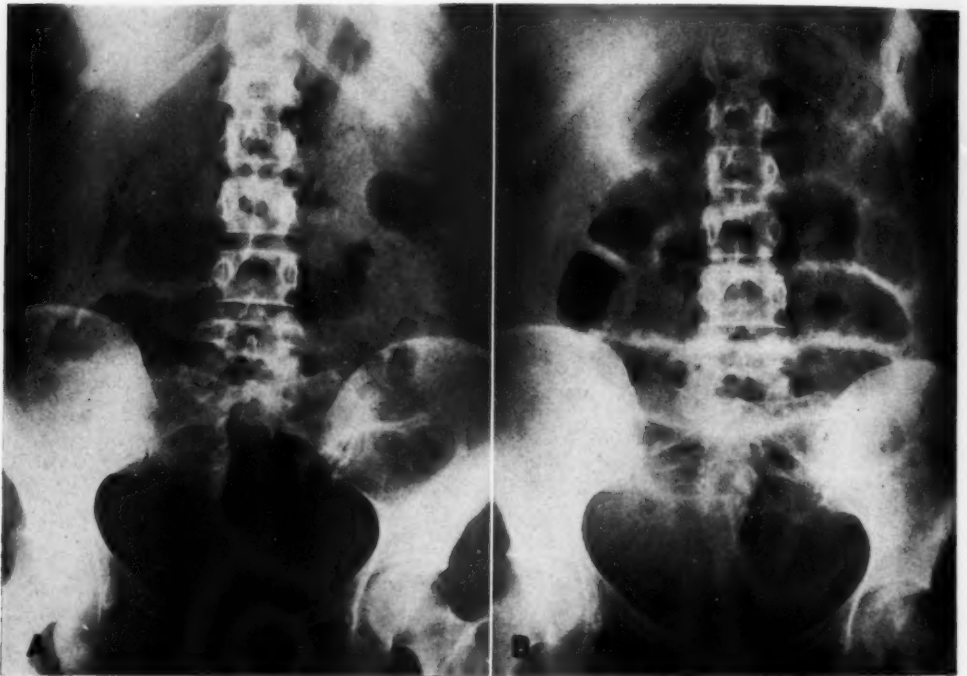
A. Roentgenogram of abdomen at 4 A.M. B. Roentgenogram at 7 A.M. showing increased distention.
